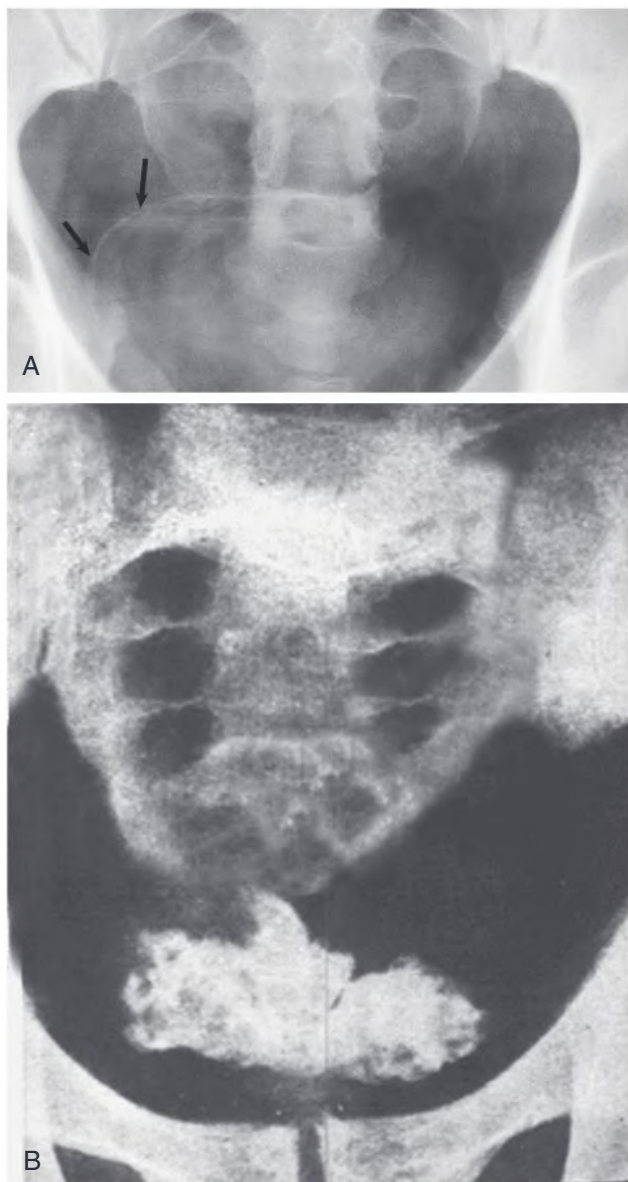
Plain radiographic Appearances in *Schistosoma haematobium* Infection. (A) Faint linear calcification of the bladder wall (arrows). (B) Dense calcifications of contracted bladder and seminal vesicles.
